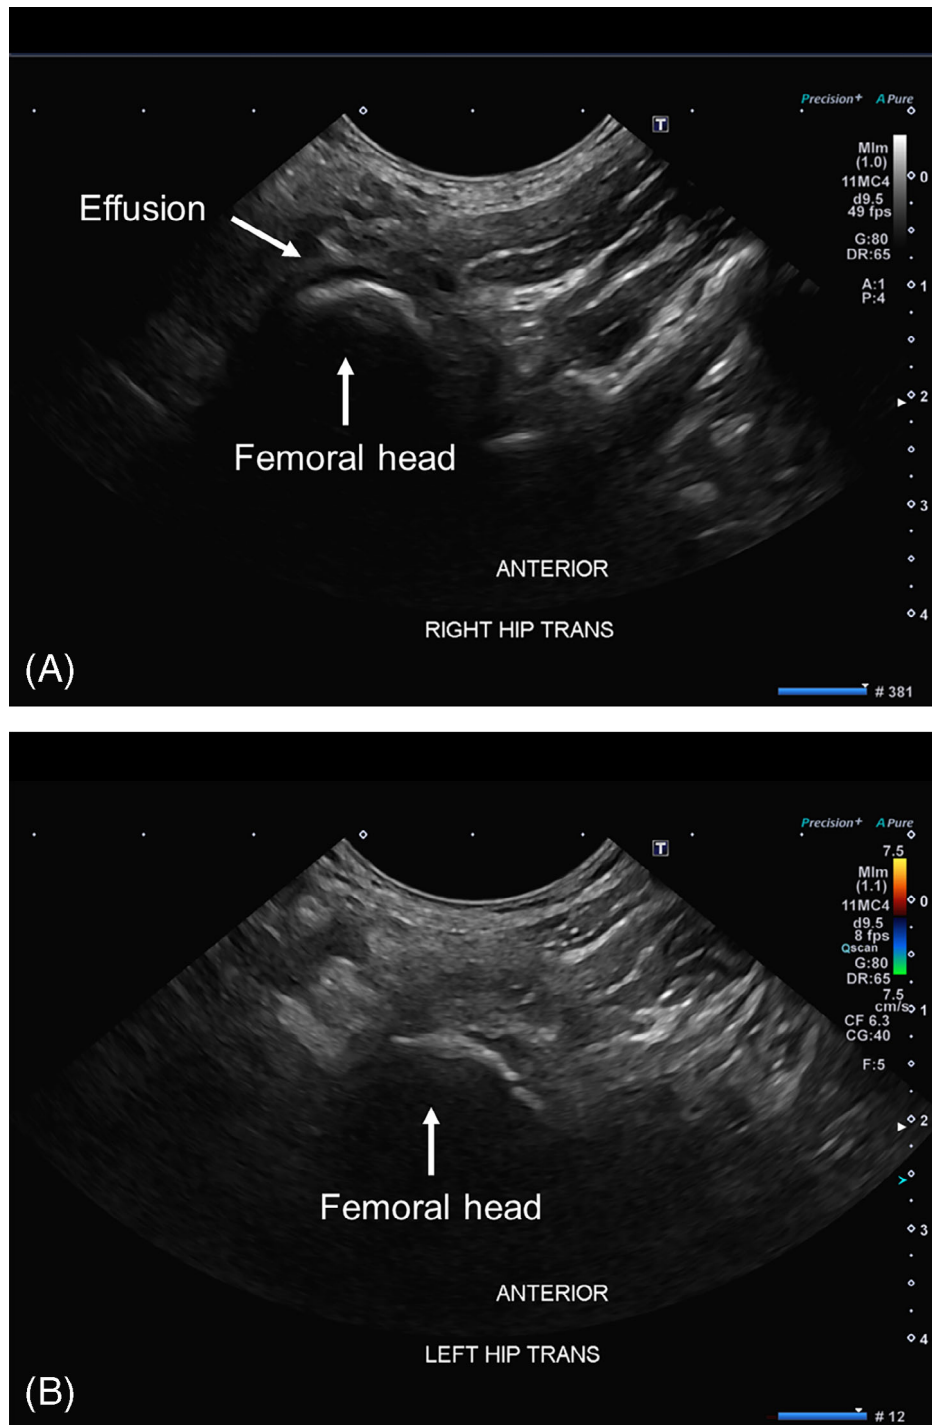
Ultrasound of bilateral hips demonstrating a small effusion on right hip (A) and normal left hip (B).
